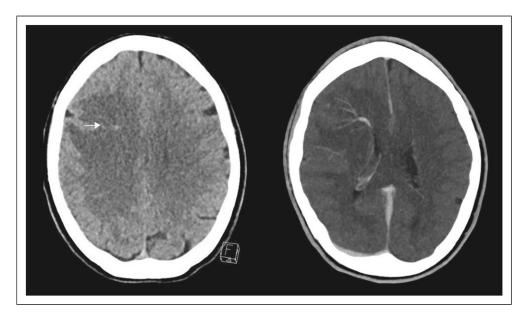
Left panel: emergent non-contrast-enhanced computed tomography (CT) brain scan, showing a massive hypodense lesion in the right frontal lobe. Right panel: contrast-enhanced CT, showing a giant DVA in the right frontal lobe.
